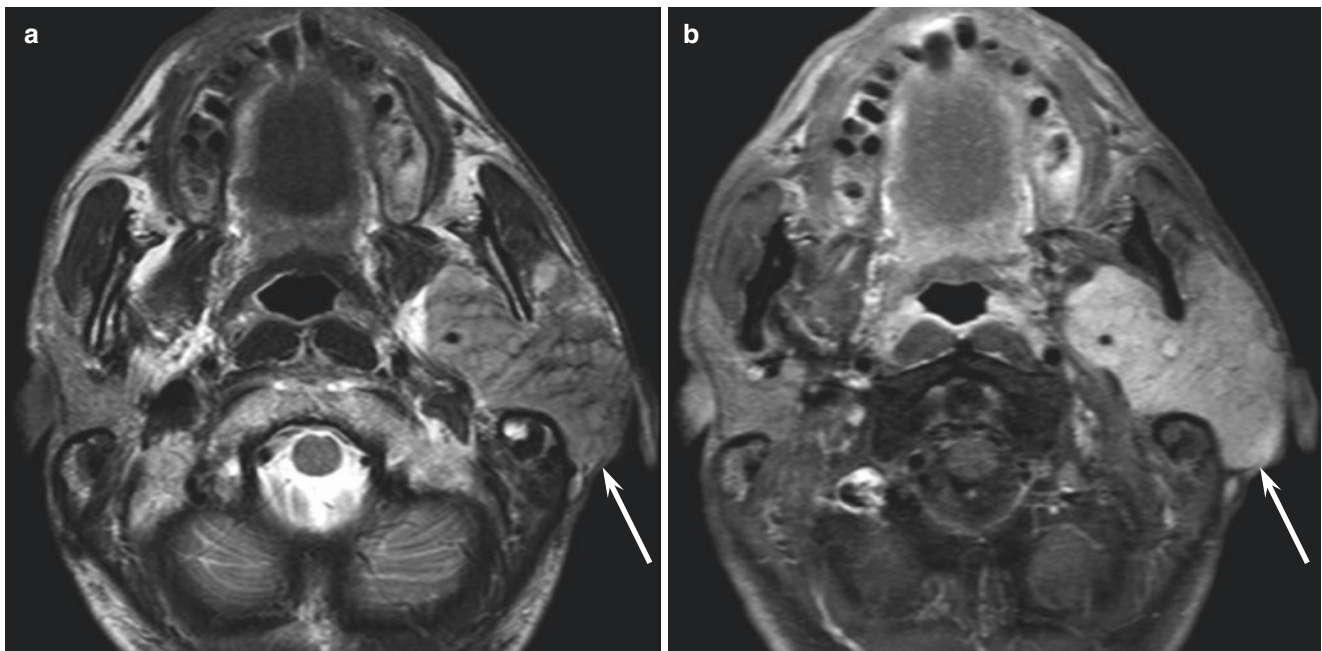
A 41-year-old man with epithelial-myoepithelial carcinoma of the left parotid gland. (a) T2-weighted image shows an ill-defined, heterogeneously iso- to hyperintense lesion (arrow). (b) Fat-suppressed
